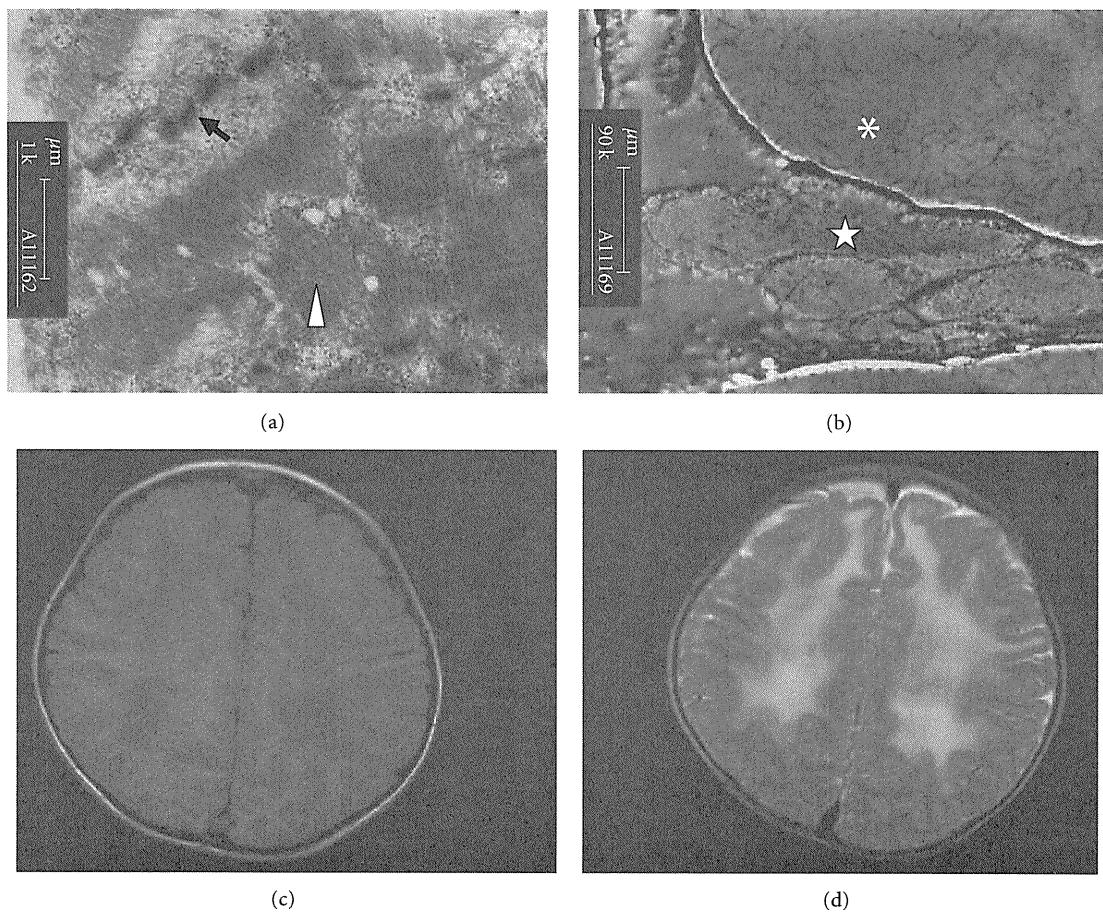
Muscular ultrastructure and brain MRI findings in a patient with congenital muscular dystrophy. In Figure 6(a), the myofibril Z lines in a muscle cell were ruptured (†), and the filaments between Z lines were arranged disorderly (Δ). Figure 6(b) showed the fatty degeneration of myofibrils (*) in a muscle cell with completely vanished sarcolemma, and large quantity of collagenous fibers (☆) were observed in the endomysium (Bar = 1 μm). Figures 6(c) and 6(d) were cranial MRI findings revealing the reduced signal intensity in T1WI while increased one in T2WI, respectively, in bilateral frontal and parietal lobes, both indicating leukodystrophy.
